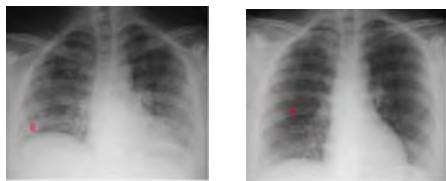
Left - Chest Radiograph at Sub-maximal Inspiration and Right - Chest at Full Inspiration. These CXRs belong to the same patient and were taken at the same time of day on two consecutive days. The CXR on the left, at sub-maximal inflation, loses valuable diagnostic information.
